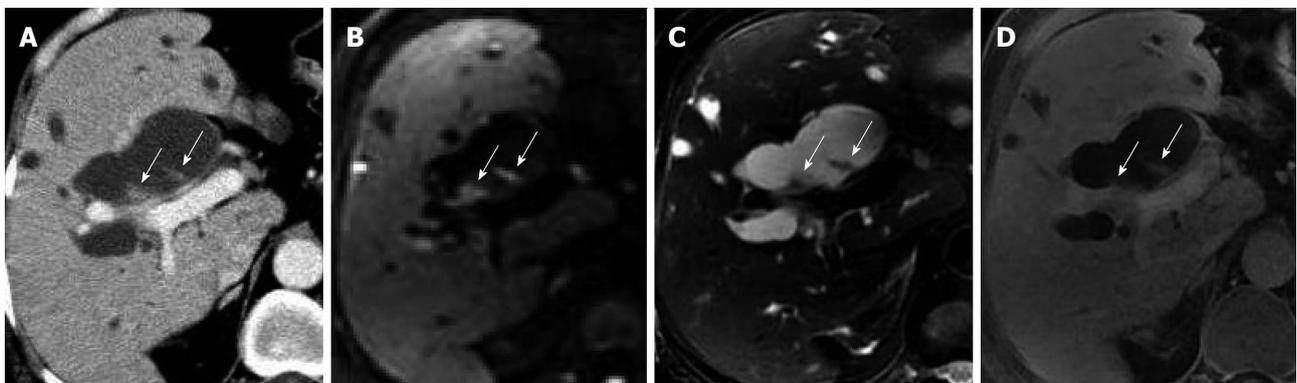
Seventy-two-year-old female patient with malignant intraductal papillary mucinous neoplasm of the bile duct (case 3). A: Axial image of enhanced computed tomography in the portal venous phase showed extensive intra- and extrahepatic bile duct dilatation with multiple hydra-like protrusions (arrows); B: Dilation appeared hyperintense (arrows) with diffusion-weighted imaging; C: Hypointense (arrows) with T2-weighted imaging; D: Gadolinium-ethoxybenzyl-diethylenetriamine-pentaacetic acid-enhanced magnetic resonance imaging in the hepatobiliary phase revealed no hyperintense bile with distribution of the contrast agents in the dilated bile duct, indicating a large amount of mucin retention, which was confirmed by endoscopy.
